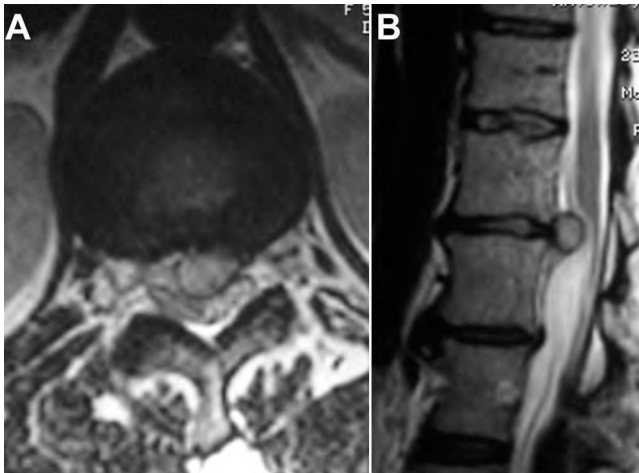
Axial (A) and sagittal (B) T₂-weighted magnetic resonance images of the thoracic spine showing a large T12–L1 herniated disc compressing the spinal cord.
